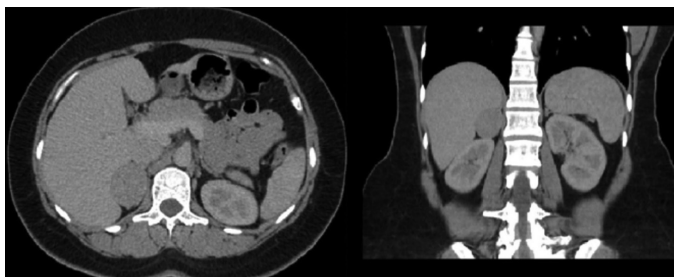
Contrast computed tomography image of the adrenocortical oncocytic carcinoma
